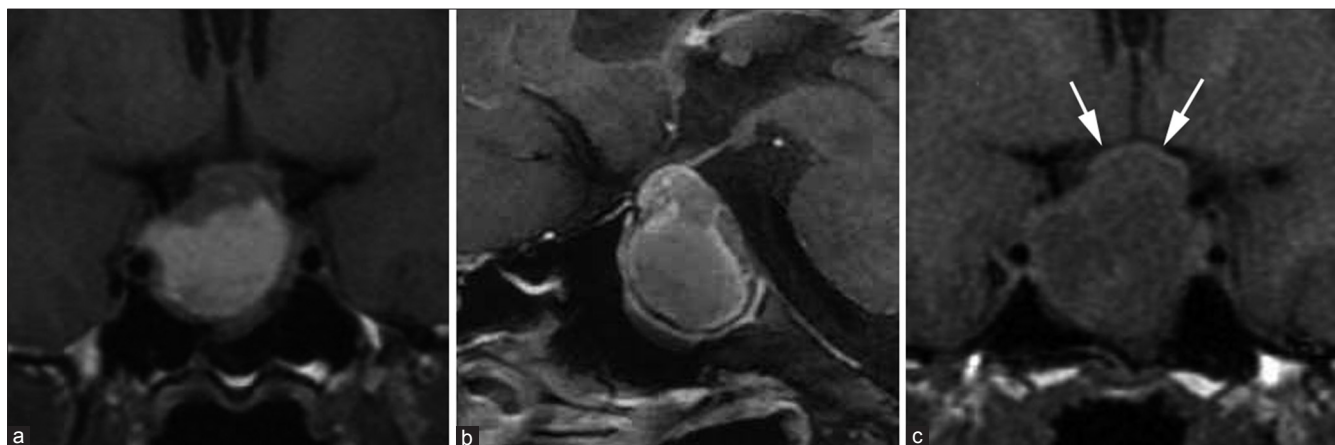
MR images obtained 2 weeks (a, b) and 3 weeks (c) after onset, (a) coronal T1-weighted image demonstrated intra- and suprasellar mass with a central area of high signal intensity consistent with hematoma of subacute phase. The hyperintense signal may correspond to hemoglobin degradation content as extracellular methemoglobin, (b) sagittal postgadolinium T1-weighted image showed rim enhancement of hematoma capsule, (c) coronal T1-weighted image demonstrated enlargement of pituitary hematoma resulting in compression of the chiasm (arrows). No sign of rebleeding was detected. Compared with MR images obtained 2 weeks after onset (a), the compression of chiasm was markedly worsened for this one week (c, arrows)
